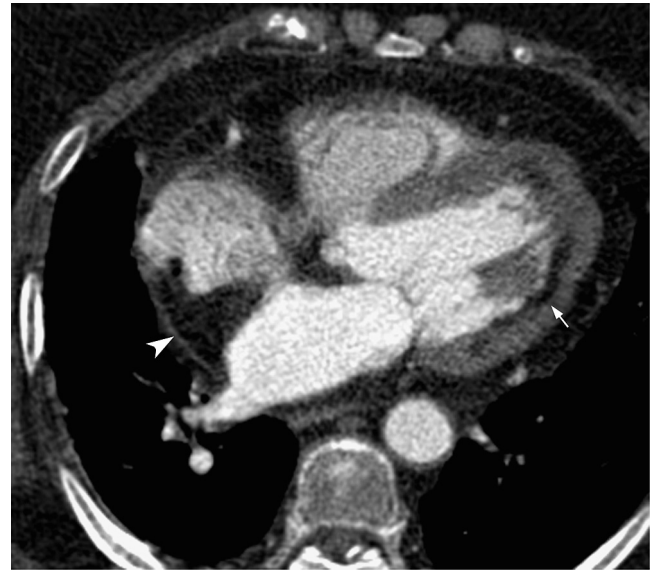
Axial contrast-enhanced computed tomography, showing an acute subendocardial infarction in the left anterior descending and diagonal territory that involve the mid-to-apical left ventricular free wall (arrow). The low attenuation myocardium infarction can be clearly distinguished from normal myocardium. Lipomatous hypertrophy of the interatrial septum is also present (arrowhead).
